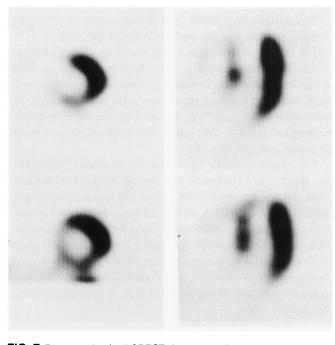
Post-exercise (top) SPECT short axis (left) and long axis (right) slices demonstrate large perfusion defects in the septal region, and comparable slices (bottom) presenting minimal redistribution after resting injection of ^{99m}Tc MIBI.
